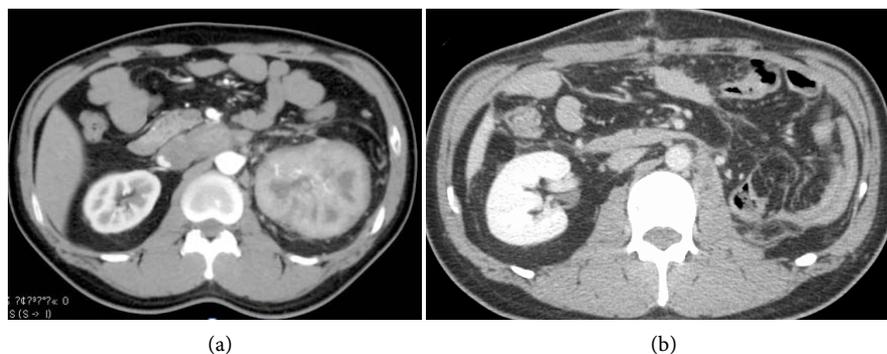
(a) Preoperative computed tomographic scan showing a large enhanced mass in the left kidney; (b) Postoperative computed tomographic scan showing no recurrences and other metastases.
